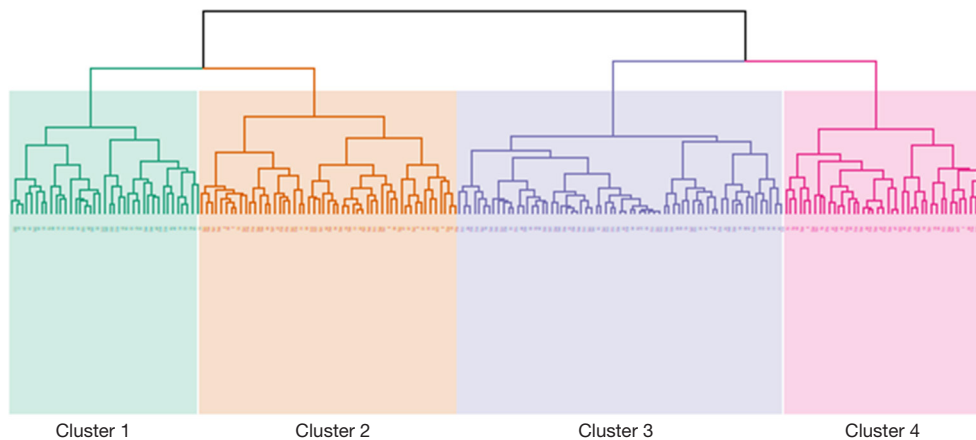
Dendrogram of the four clusters identified. Cluster 1 (n=53, 26.4%): older Chinese males with high BMI and comorbidity burden, and higher baseline FVC percentage predicted. Cluster 2 (n=67, 33.3%): younger female non-smokers with low comorbidity burden, groundglass changes on HRCT, positive ANA titre $\geq 1:160$ and lower baseline FVC percentage predicted. Cluster 3 (n=42, 20.9%): male smokers with low comorbidity burden, emphysema on HRCT and high baseline lung function. Cluster 4 (n=39, 19.4%): non-Chinese ethnicity, mainly Indian, with high BMI, low baseline lung function and high proportion of IHD and previous pulmonary TB. BMI, body mass index; FVC, forced vital capacity; HRCT, high-resolution chest computed tomography; ANA, anti-nuclear antibody; IHD, ischemic heart disease.
